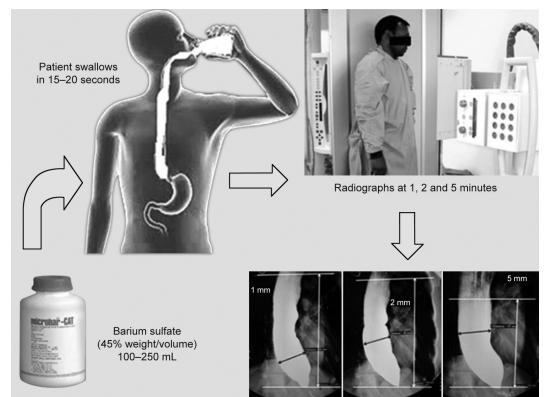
Technique of timed barium esophagogram. Barium sulfate suspension (45% weight/volume) is swallowed by patient in standing position. Three radiographs are taken 1, 2 and 5 minutes later in left posterior oblique position
